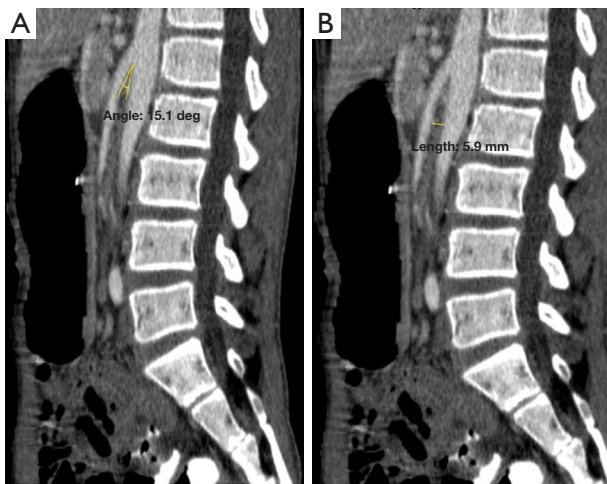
Sagittal view of initial contrast-enhanced computed tomography scan of the abdomen showing: (A) the aortomesenteric angle is 15.1° , while (B) the aortomesenteric distance is 5.9 mm, suggestive of a SMA syndrome. SMA, superior mesenteric artery.
